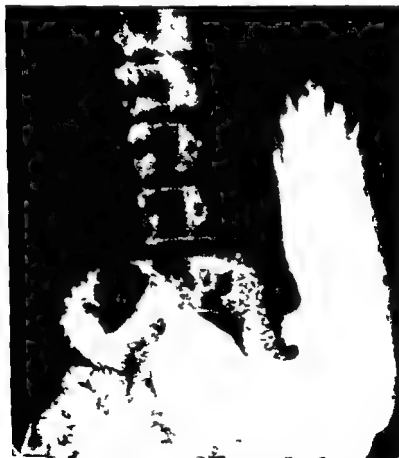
Case 1 Three years later the duodenal deformity is still present along with a large ulcer of the stomach (From Frank Huber and Charles G. Huntington Gastric Retention and Gastric Ulcer *Amer J Roentgenol* 60 82 1943 Reprinted by permission of the authors and the *American Journal of Roentgenology*)
